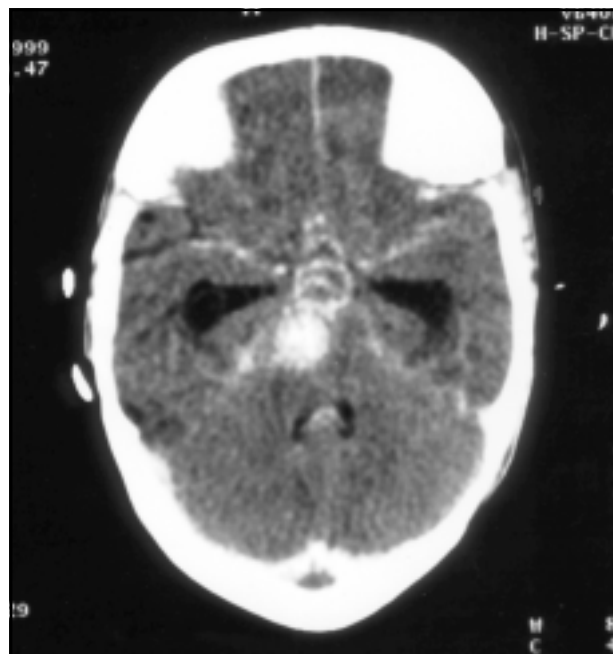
CT scan showing a giant saccular aneurysm possibly emerging from the left basilar artery.
